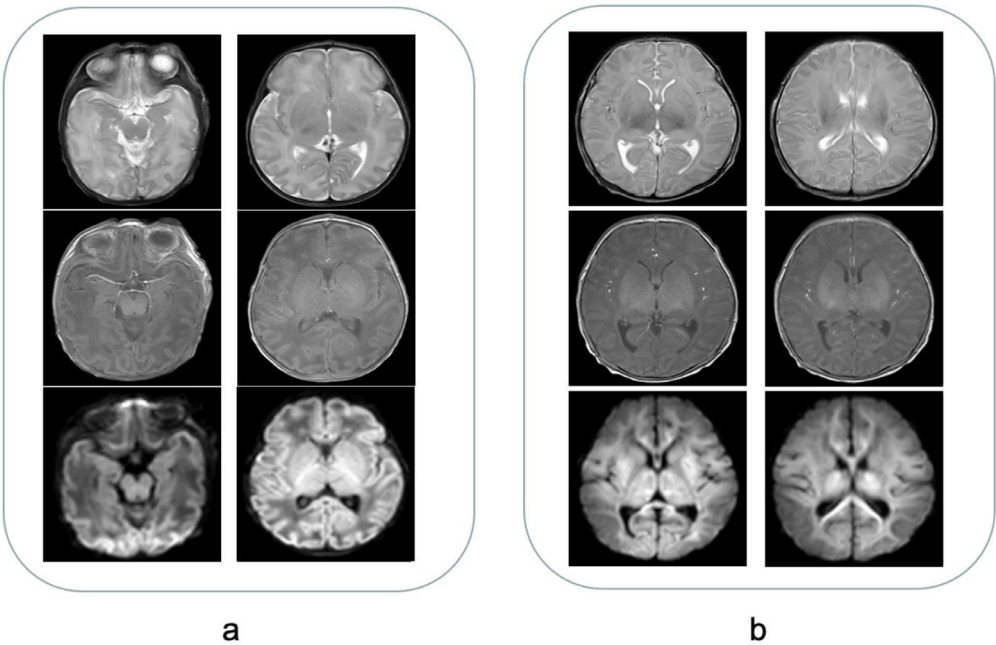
Asphyxiated premature infants undergo magnetic resonance imaging within seven days after birth to observe the effect of asphyxia on the nervous system.
